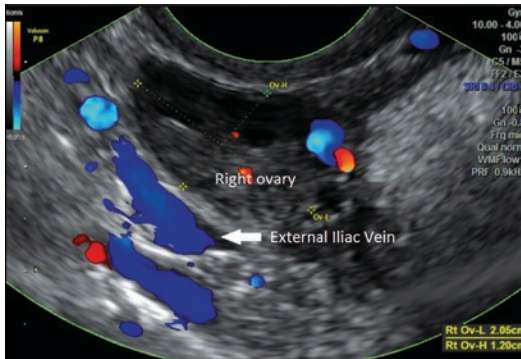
A transvaginal sonography image in the sagittal plane demonstrating the location of the right ovary in relation to the right external iliac vein
